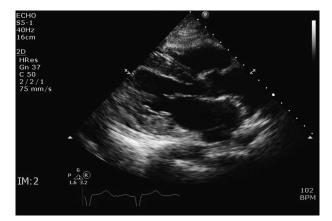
A surface echocardiogram at presentation shows moderate concentric LVH and speckling of the myocardium concerning for an infiltrative process. LVH, left ventricular hypertrophy.
